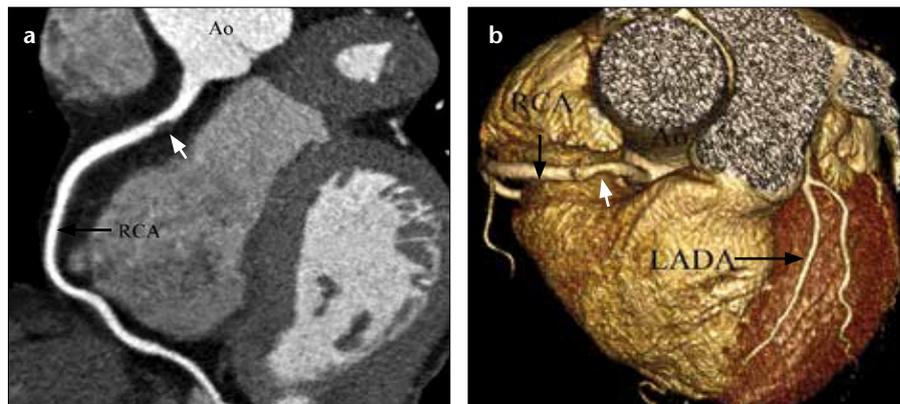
a, b. A 54-year-old asymptomatic woman with three risk factors, which are diabetes mellitus, family history, and smoking. Curved planar reformatted (a) and volume-rendered (b) CT angiography images show a noncalcified soft plaque (white arrows), which is causing a nonsignificant (<50%) stenosis in the proximal segment of the RCA (Ao, aorta; LADA, left anterior descending artery; RCA, right coronary artery).
